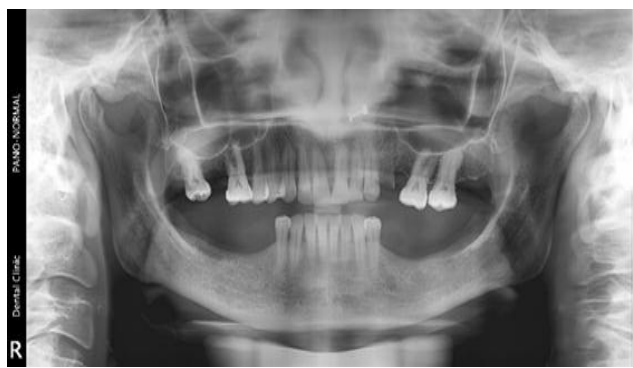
Orthopantomogram of patient
